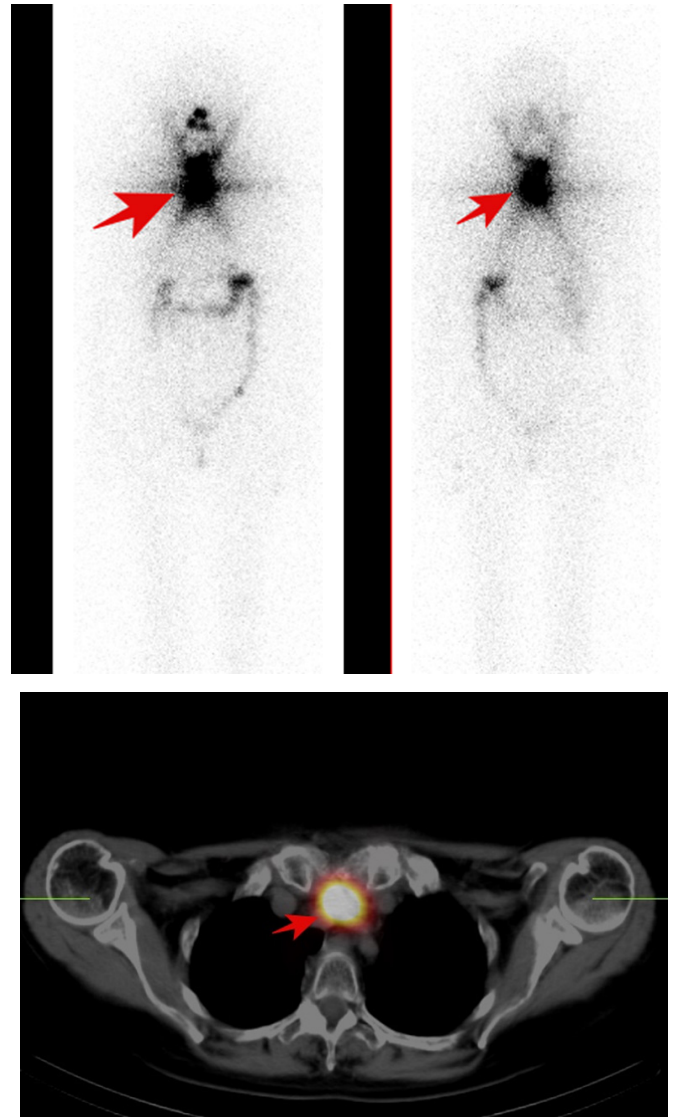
(A) Posttherapeutic ¹³¹I planar whole-body scan showed radioiodine uptake in thyroid bed and residual infiltration in the left mediastinum (B) Image fusion of CT and iodine SPECT scan of the thoracic region showed radioiodine uptake in residual infiltration in the left mediastinum.
